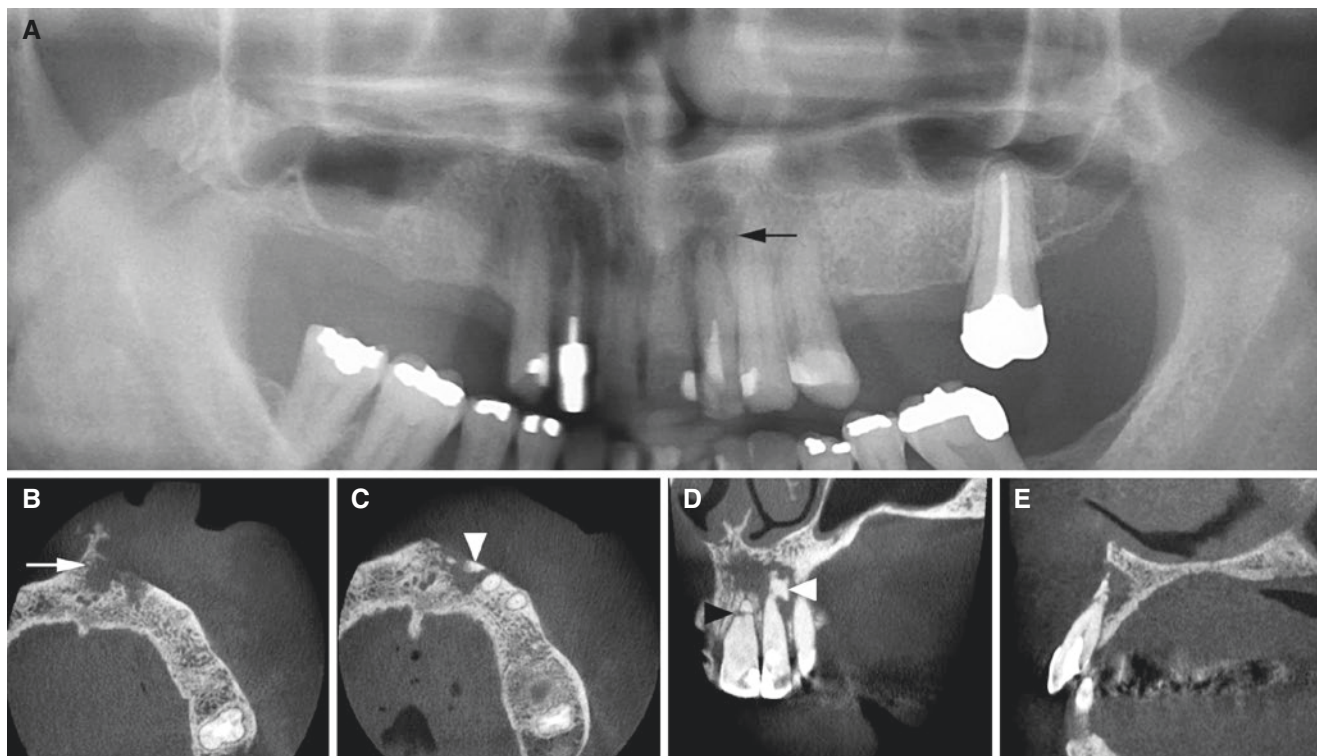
Osteomyelitis with sequestration, maxilla; 54-year-old female with fistula and pus from the front region of the upper jaw (lateral incisor). (A) Panoramic view shows diffuse bone destruction (arrow). (B, C) Axial, (D) coronal, and (E) sagittal CBCT images show
